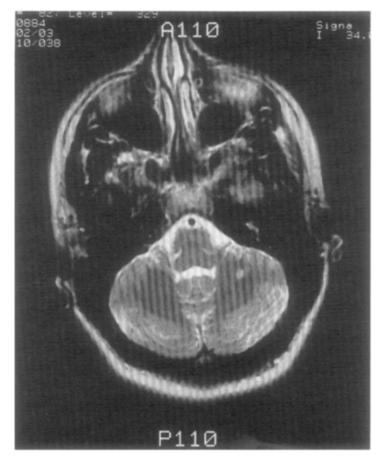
T2-weighted MR image of the cerebellum and brainstem shows a prominent lesion in the white matter of the left cerebellum.
